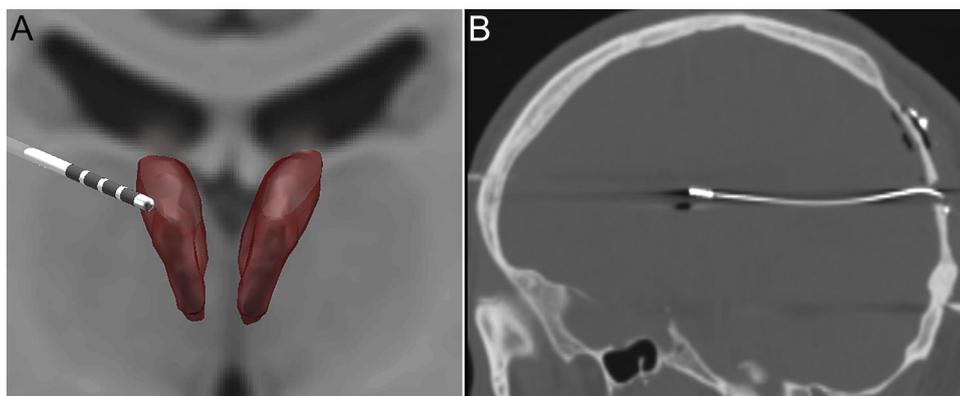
Image of two patients with anterior thalamic nucleus misses. The right electrode position in Patient 9 (A) was located slightly lateral to the margin of the anterior nucleus of the thalamus (red). Oblique sagittal CT in the patient 6 (B) shows a superior deflection of the electrode beginning near the margin of the atrium of the lateral ventricle.
